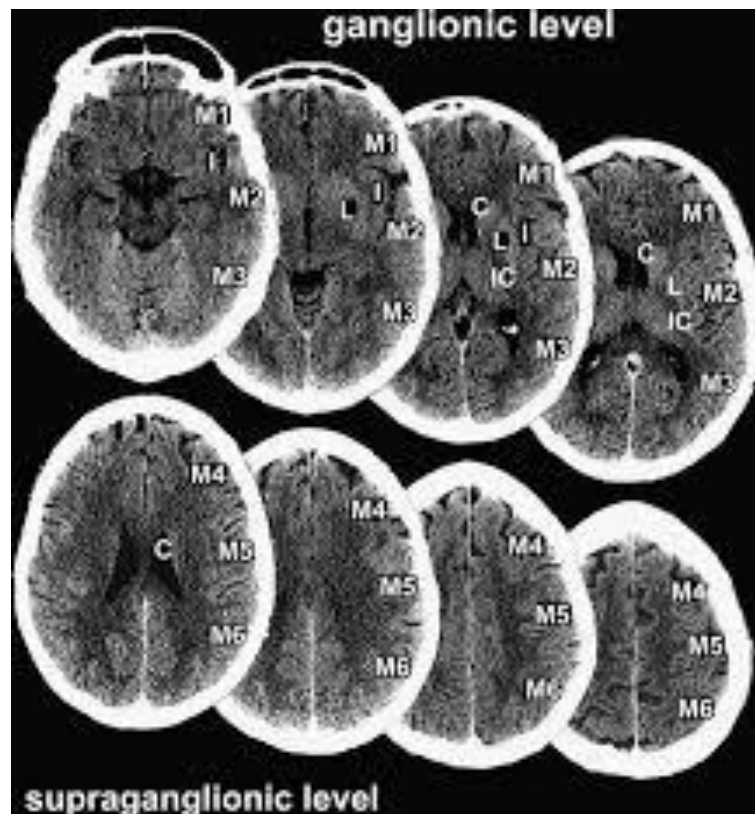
Another representation of the ASPECTS evaluation in CT scan slices for diagnosing ischemic stroke in the MCA territory.
